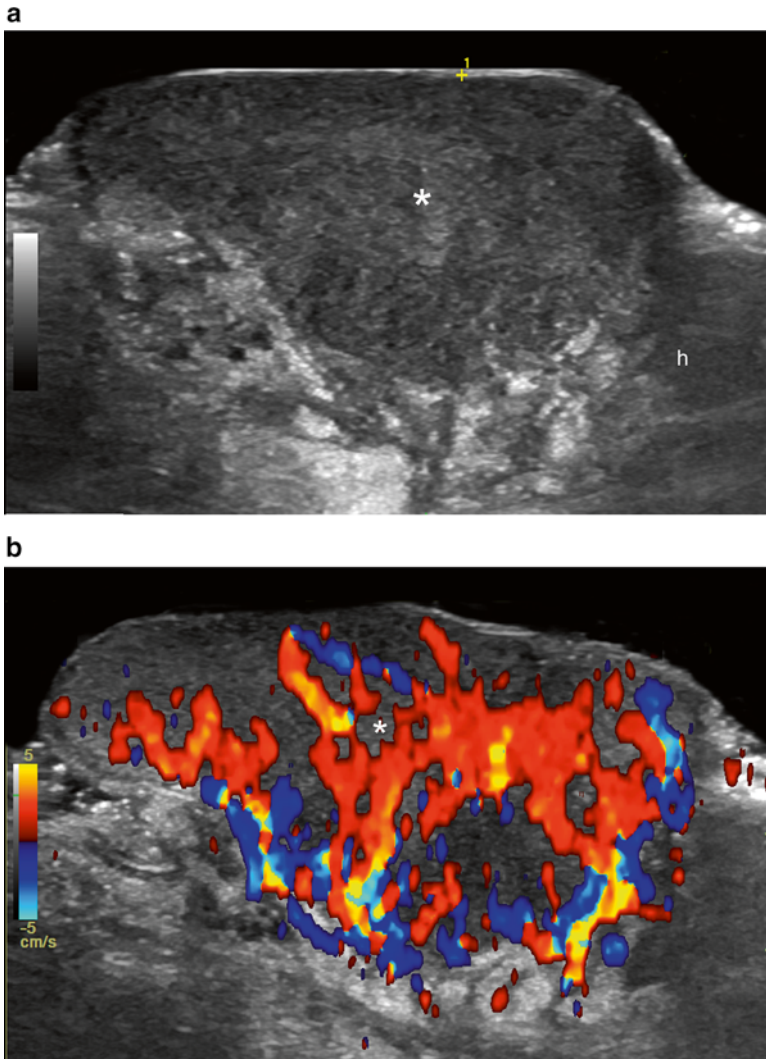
(a) (Top). Melanoma . Grey scale shows hypoechoic oval shaped mass (*) involving dermis and hypodermis (h). (b) (Bottom). On color Doppler prominent vascularity is detected within the mass (*)
